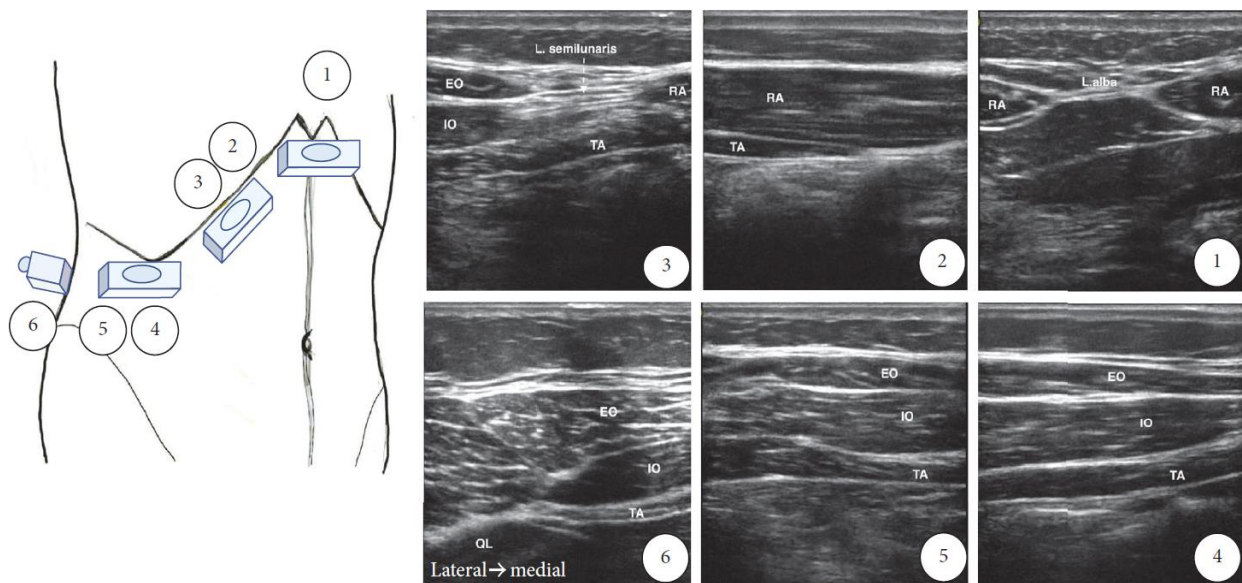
Ultrasound identification of the transversus abdominis plane.
